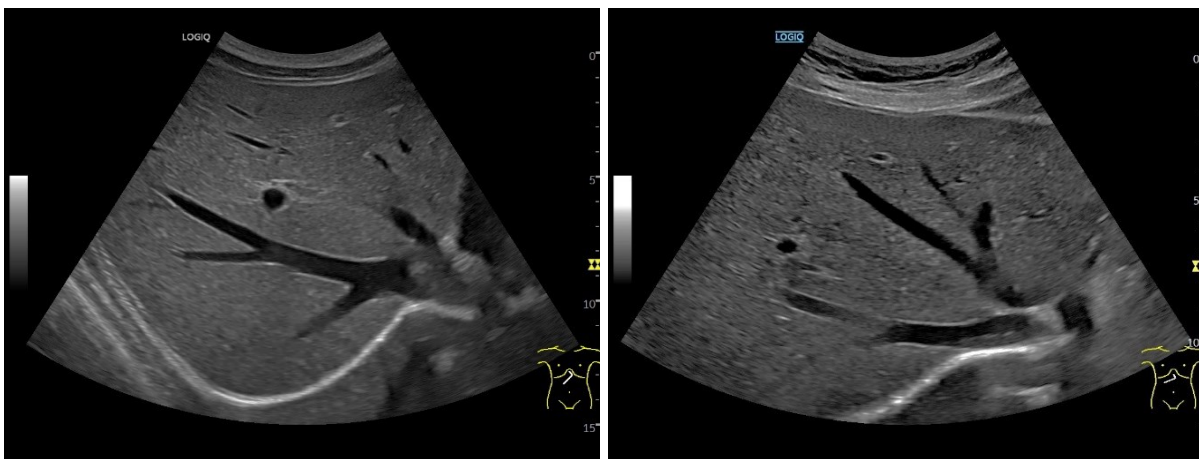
Oblique subcostal ultrasound view of the hepatic veins, demonstrating their normal branching pattern and anechoic appearance
